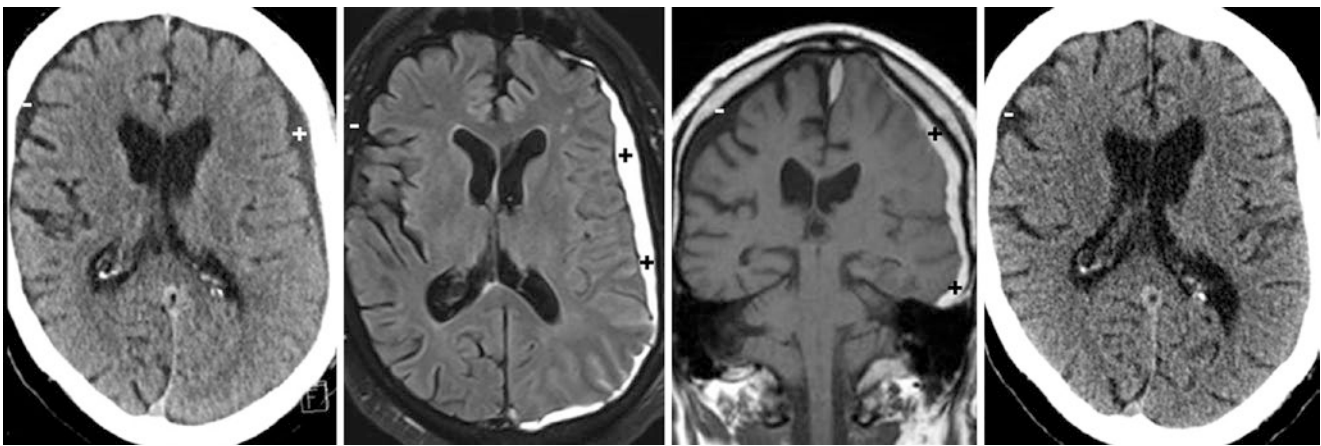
Comparison case: chronic SDH. In a 72 year old without known trauma, a NECT (*left*) depicted an isodense SDH (+) along the left cerebral convexity. On a 1.5T MRI with FLAIR (*left middle*) and a coronal T1WI (*right middle*), the SDH was confirmed to be subacute (bright on T2WI, FLAIR, and T1WI). Compare this to the right-sided volume loss with SAS prominence (-). The left-sided SDH had resolved 30 days later on a repeat NECT (*right*)
